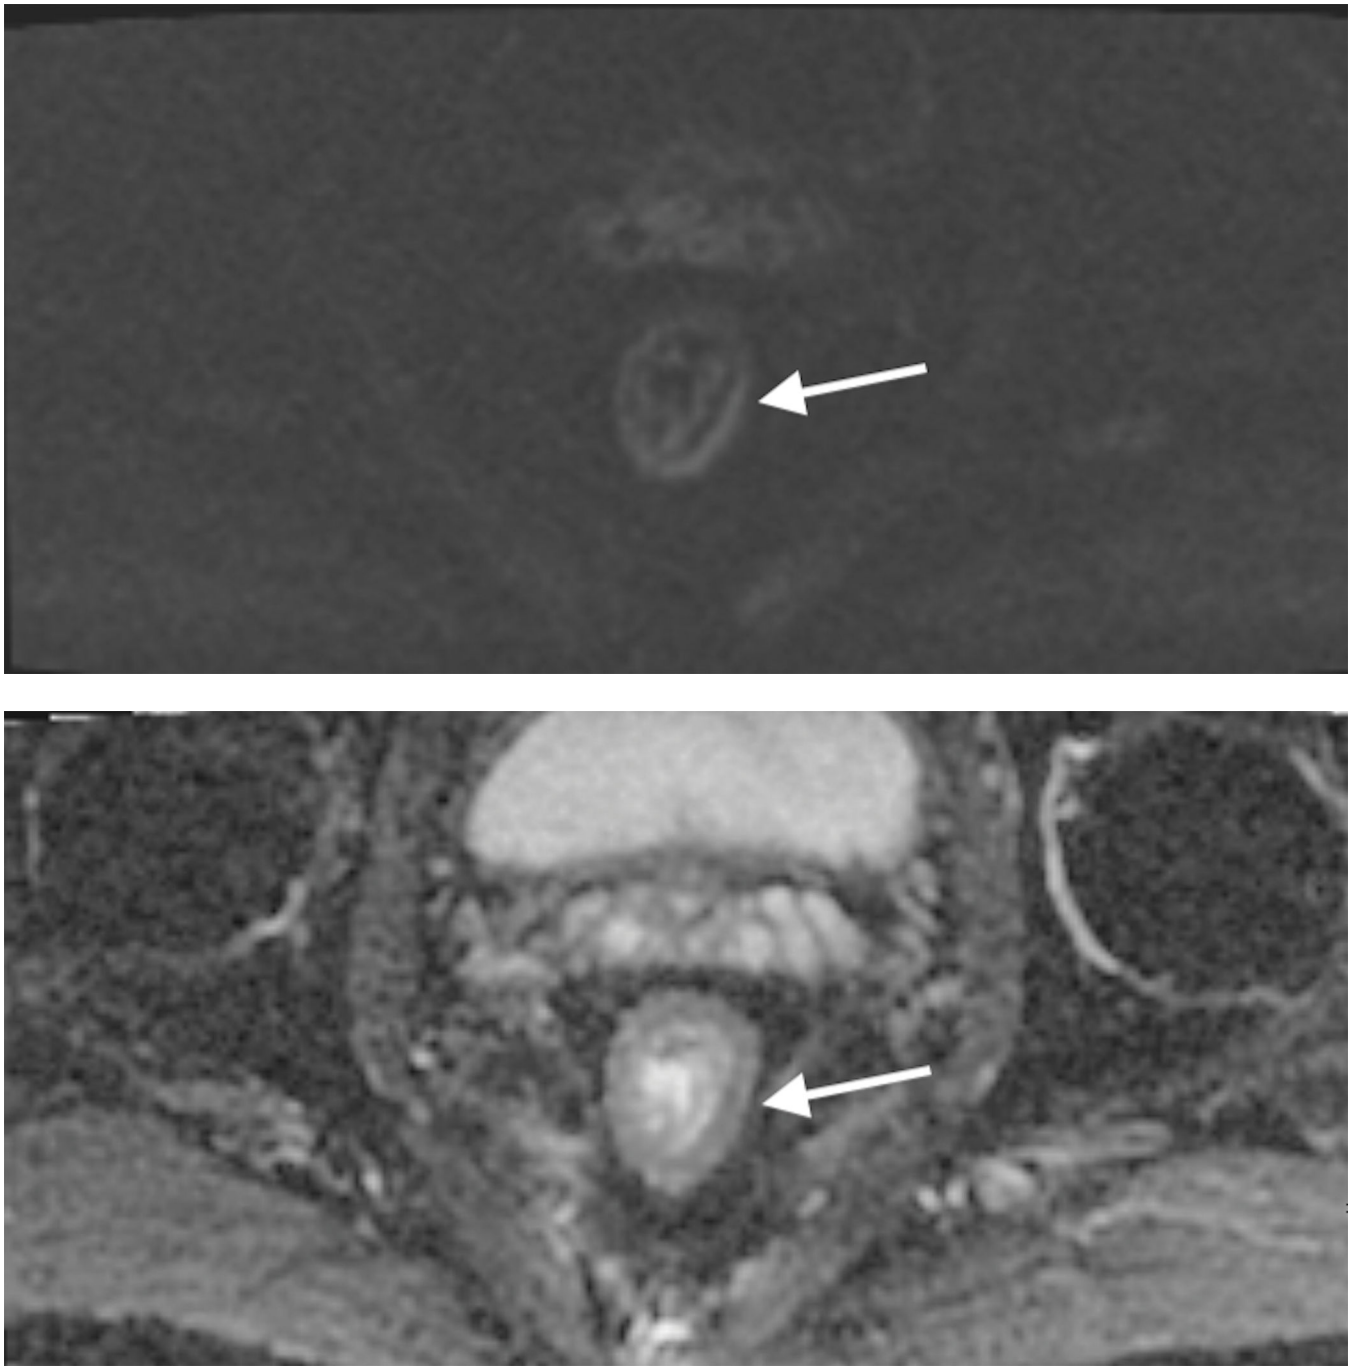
Restaging MRI in a patient with complete response after chemoradiation. (A) Axial T2W, (B) DWI, and (C) ADC map shows a T2W dark scar in the left lateral rectal wall with no focal restriction diffusion.
